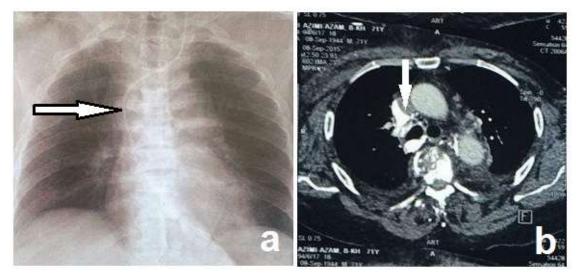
a) CVC is seen in chest-X-ray that was inserted from left side. b) A crescent filling defect in SVC was seen in CT-Angiography adjacent to CVC in favor of CRT.
